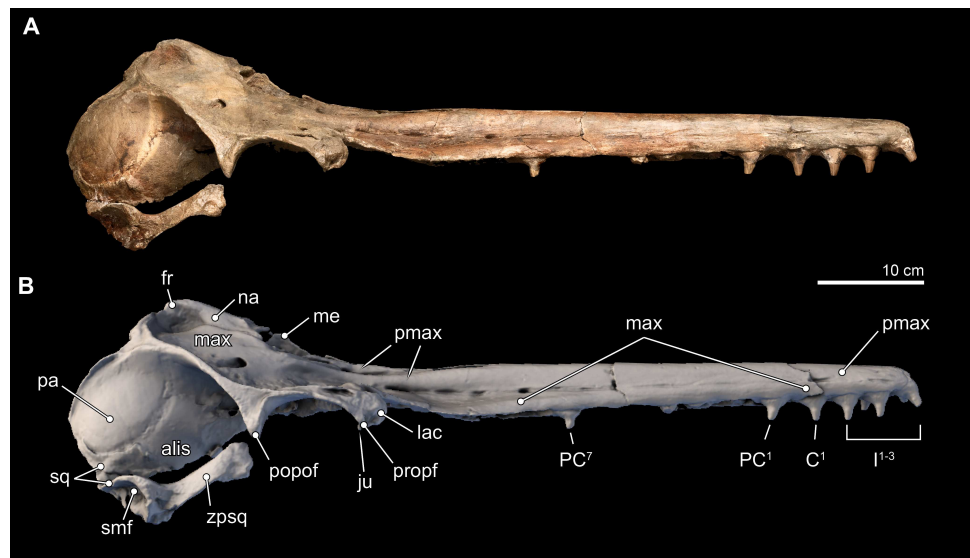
Skull in lateral view. Right lateral views of the type skull of *Isthminia panamensis* (USNM 546125) from (A) photographs and (B) orthogonal digital three-dimensional polygon model prepared from CT data, with lighting and color modifications using the Smithsonian X 3D browser. See <http://3d.si.edu/explorer?s=jn4ynp> to measure, modify, or download this model.
